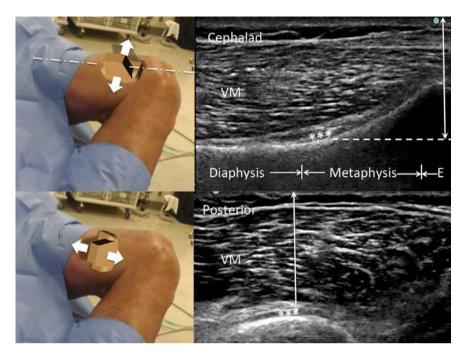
Ultrasound-guided superior medial genicular nerve block. (Upper panel) The long axis of the femur, from cephalic to caudal, at the junction of epiphysis (E) and diaphysis. The genicular nerves ran in the fascial expansion (*) deep to the vastus medial muscles (VM) in the vicinity of the genicular arteries. (Lower panel) The short axis of the femur revealed the fascial expansion of the same depth.
